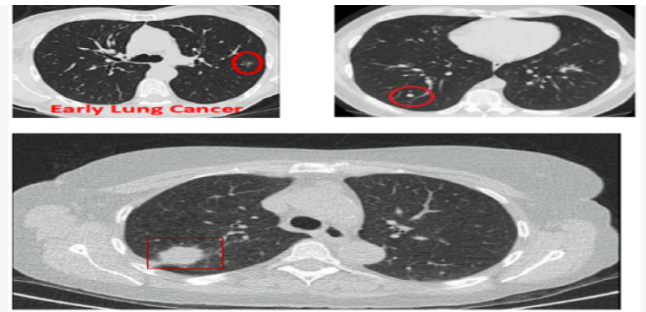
CT Scan Visualization Using Maximum Intensity Projection Technique
